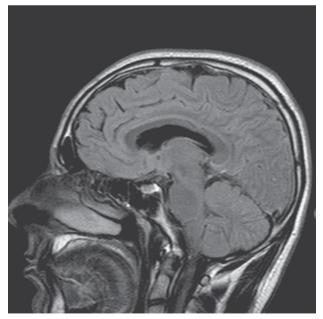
(a) MRI of the brain: healthy
